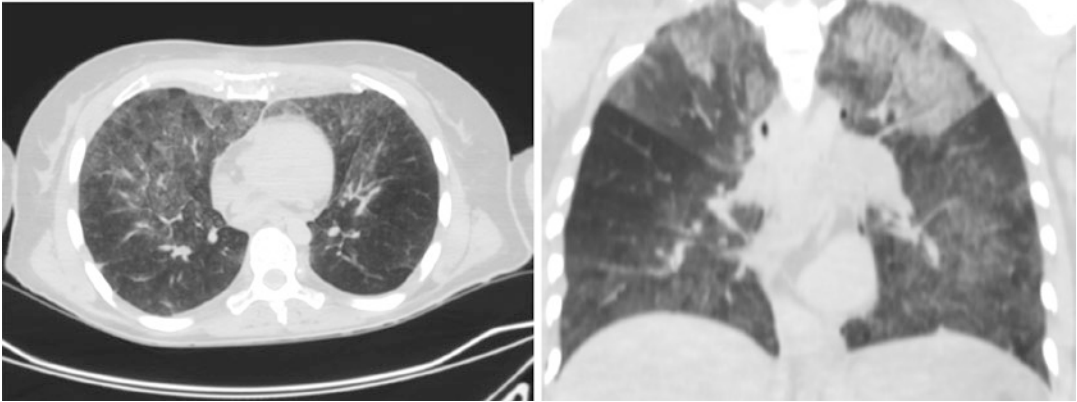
Axial and coronal pulmonary CT performed in a woman victim of an air disaster, showing bilateral patchy “ground-glass” areas in the lung parenchyma due to drowning after air crash
